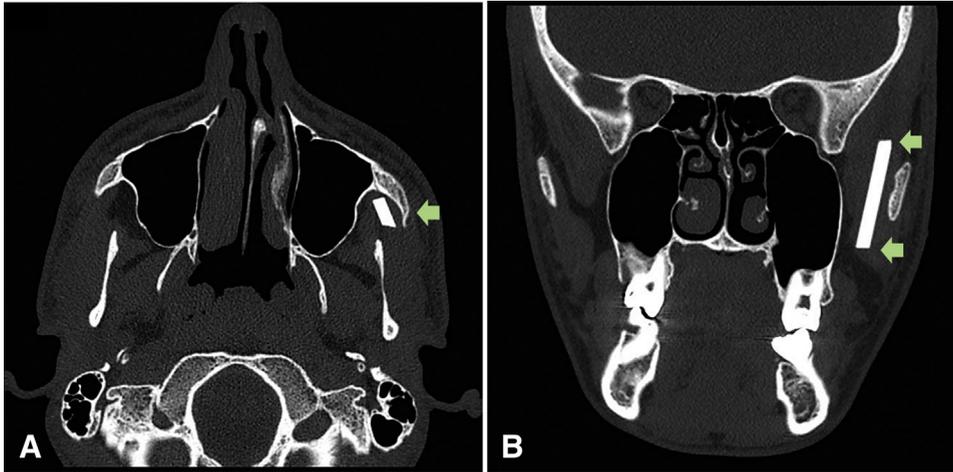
Computed tomography (CT) scan of head and neck without contrast. (A) Axial CT scan revealed a well-delineated radiopacity located between the coronoid process and the zygomatic-maxillary suture (arrow). (B) Coronal CT scan showed a foreign body compatible with a 3.5 cm \times 1 cm glass fragment embedded in the temporal and pterygoid muscles (arrows).
